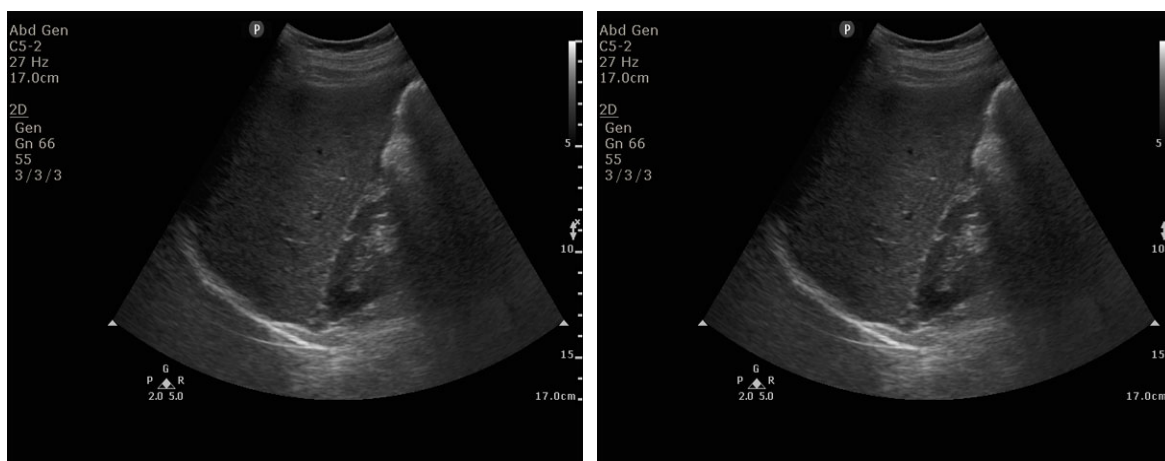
A - Real Ultrasound Machine
